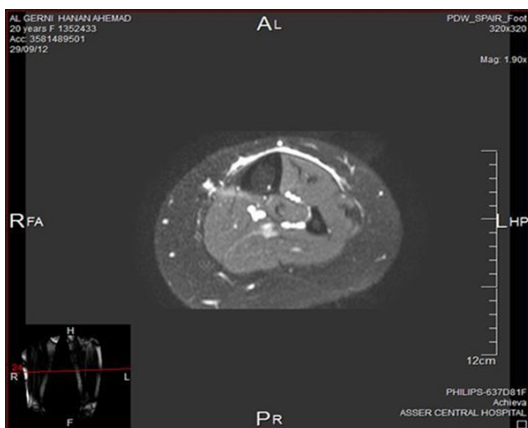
T2-weighted magnetic resonance imaging (MRI) scan (axial view) showing intense fascial enhancement.
